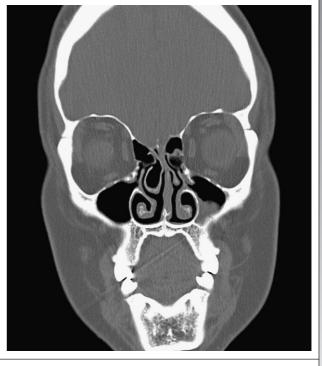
• Coronal computed tomographic image demonstrating concha bullosa involving the right middle turbinate.
